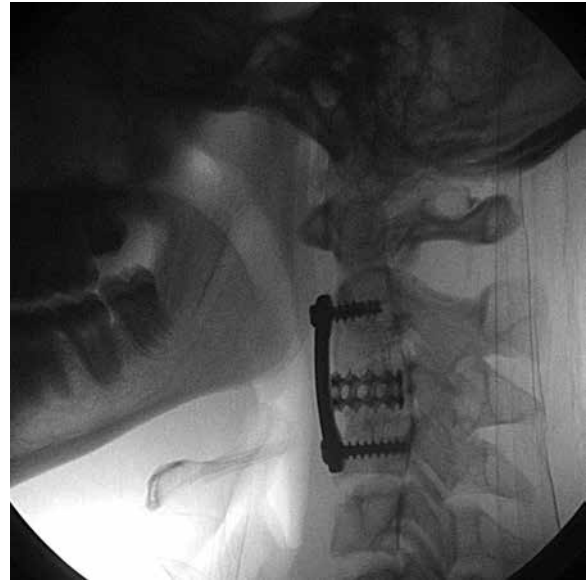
Radiographic image presenting the anterior instrumentation of the cervical spine with C2-C4 fusion.
